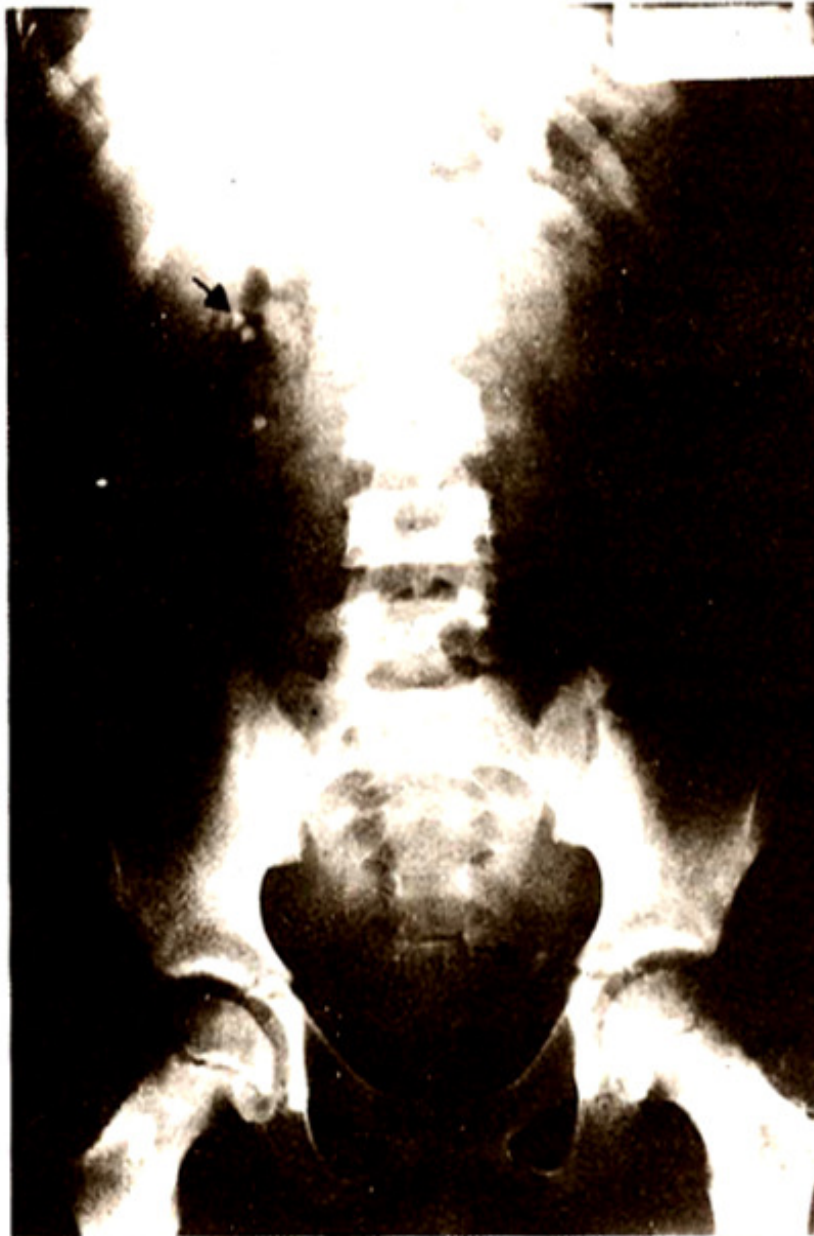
Pre-operative, plain X-ray of abdomen showing left ureteric and multiple right renal calculi.
